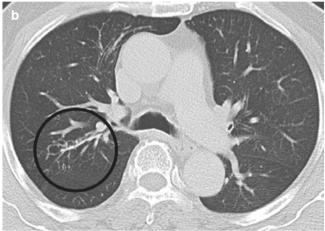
Focal bronchiectasis in this patient with nasopharyngeal carcinoma, probably related to recurrent aspiration. (a, b) Axial CT image shows focal bronchiectasis in the posterior segment of the right upper lobe. Note early bronchiectasis in the anterior segment of the right upper lobe
